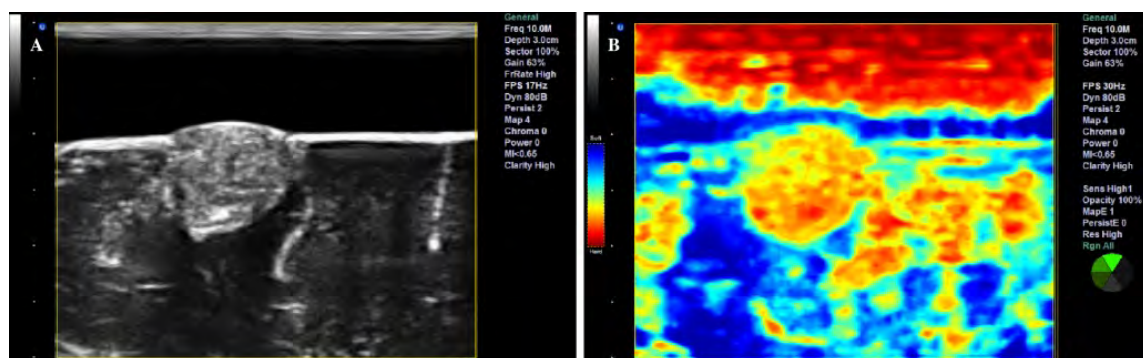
Elastography. A) Ultrasound B-mode image of a small meningeoma, and B) the ultrasound elastogram of the tumour as displayed on an Ultrasonix MDP scanner.
